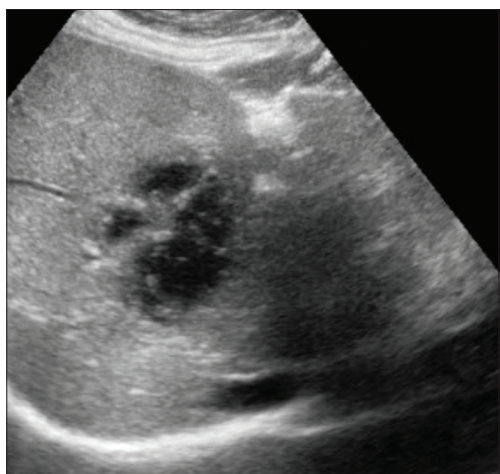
Transverse ultrasonography scan showing well-defined heterogeneous, predominantly cystic lesion, suggestive of an abscess, within the right lobe of the liver
